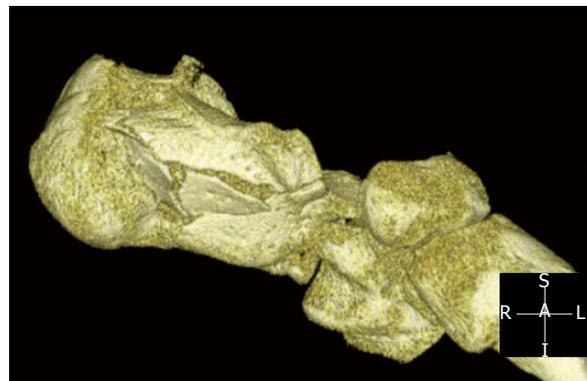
Calcaneus fracture after a ground fall (Computed tomography scan).
